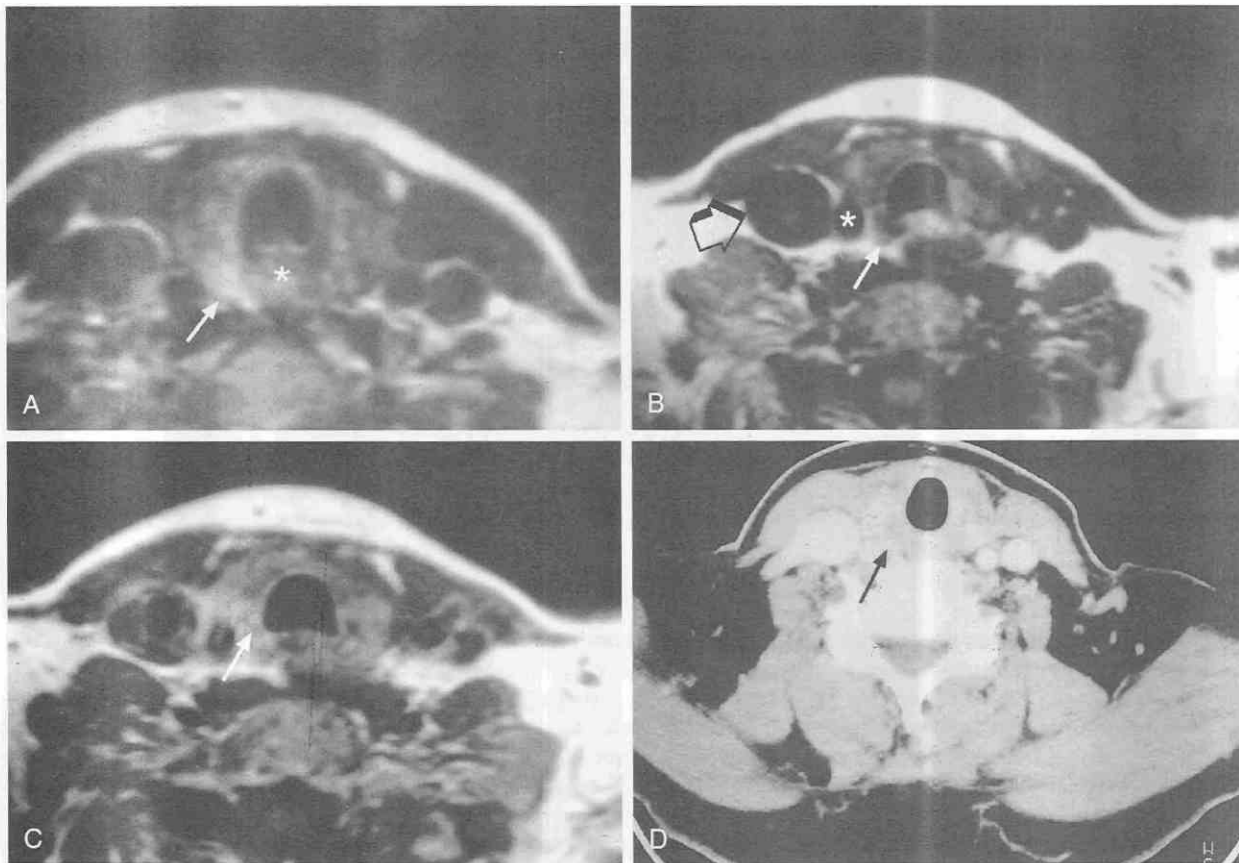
Surgically proven parathyroid adenoma. *A*, Axial T2-weighted MR image shows an ovoid mass (arrow) of increased T2-weighted signal posterior to the right lobe of the thyroid and adjacent to the esophagus (asterisk). *B*, Axial T1-weighted MR image demonstrates that the mass (arrow) is isointense to thyroid parenchyma. Flow voids can be seen in the right common carotid artery (asterisk) and right internal jugular vein (open arrow). *C*, Axial T1-weighted MR image after gadolinium contrast administration demonstrates enhancement within the lesion (arrow). *D*, Axial postcontrast CT image shows a homogeneously enhancing ovoid mass (arrow) in the right tracheoesophageal groove.
